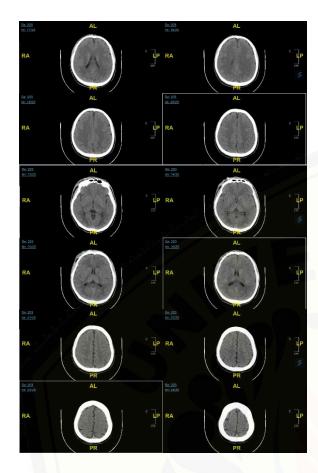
CT scan imaging, brain window
